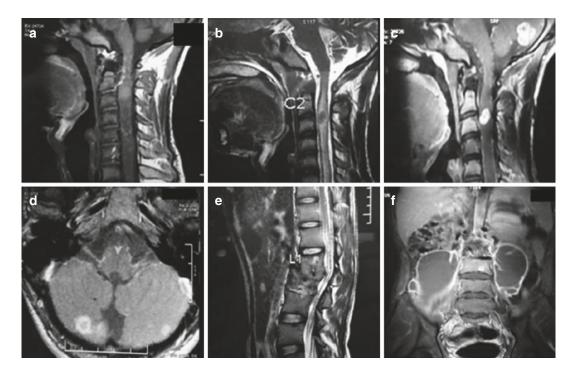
(a–f) Well-defined and homogenous enhancement human immunodeficiency virus-positive 16-year-old male patient. Multiple tuberculomas located in the cerebellum and cervical spinal cord are seen as isointense on T1-weighted image, isointense on T2-weighted image and enhanced on contrast-enhanced T1-weighted images. In addition to these tuberculomas, there are vertebral body and disc space involvement at lumbar region and bilateral psoas abscesses. The patient presented with low back pain for 2 years and headache for 2 days, and neurological examination revealed the seventh cranial nerve involvement and paraplegia (Courtesy of YR Yadav)
